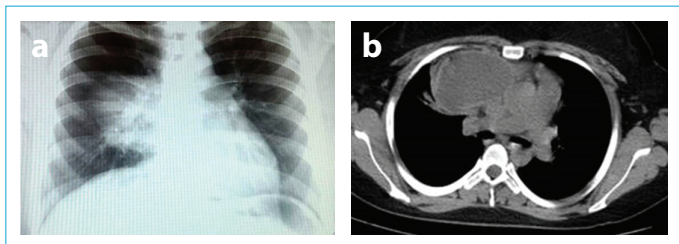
(a) A well-defined paracardiac cystic mass image on the mid-zone of the chest X-ray. (b) Paracardiac mass on thorax CT.
